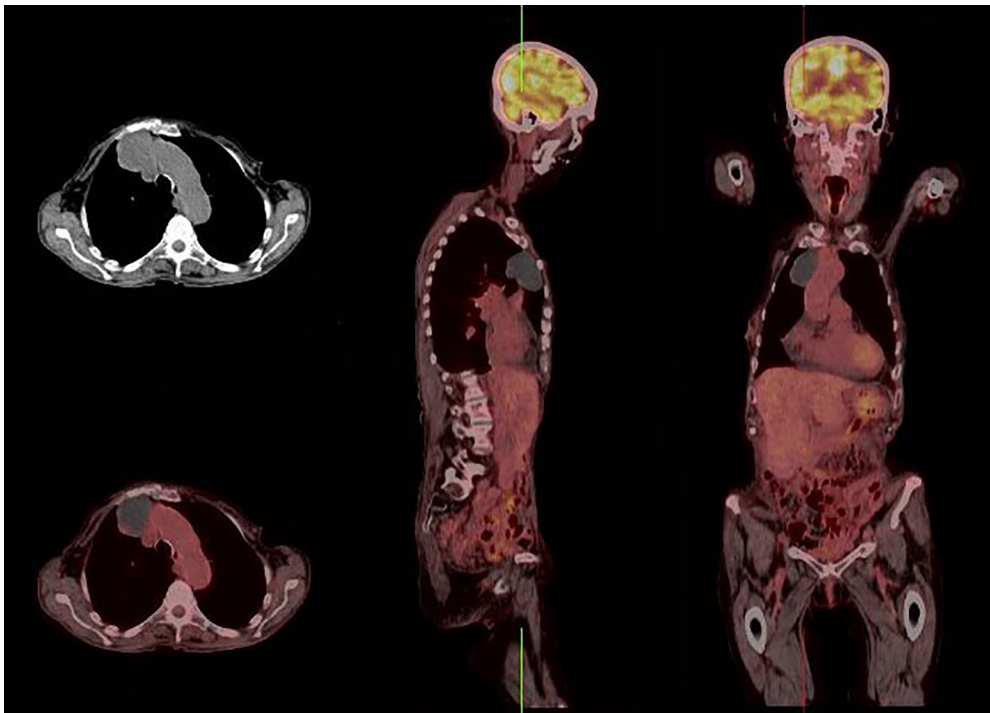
FDG-PET-CT showing a mediastinal mass without increased uptake adjacent to the ascending aorta.
